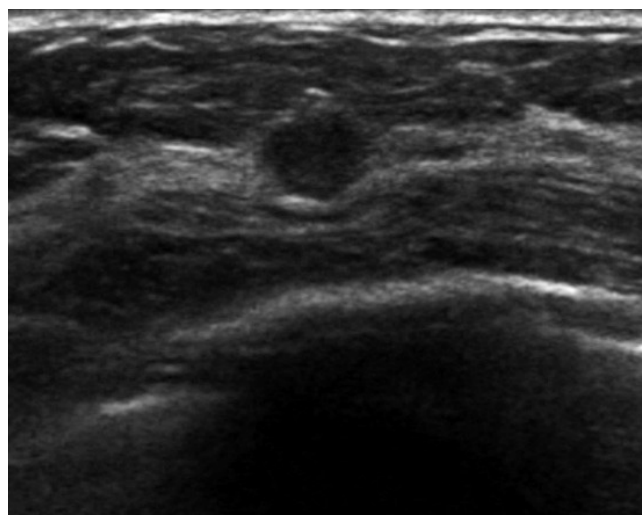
A US-detected cancer in a 49-year-old woman that was initially assessed as BI-RADS category 4A (case 2 in Table 3). US shows an ill-defined oval hypoechoic mass in right breast and it was assessed as category 4A. The pathologic diagnosis was invasive ductal cancer with ductal carcinoma *in situ*. US, ultrasound; BI-RADS, Breast Imaging Reporting and Data System.
